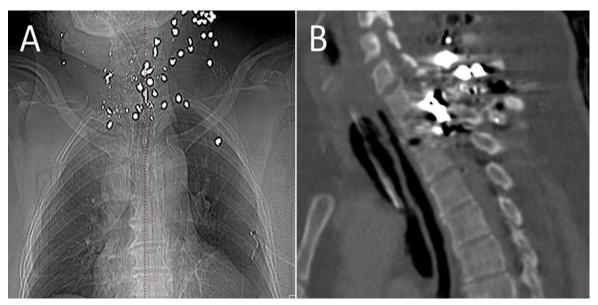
CT scan images: foreign metal bodies (A). Pellets in spinal canal in the cervicothoracic junction (B) (from *Turliuc et al.*, 2015b)
